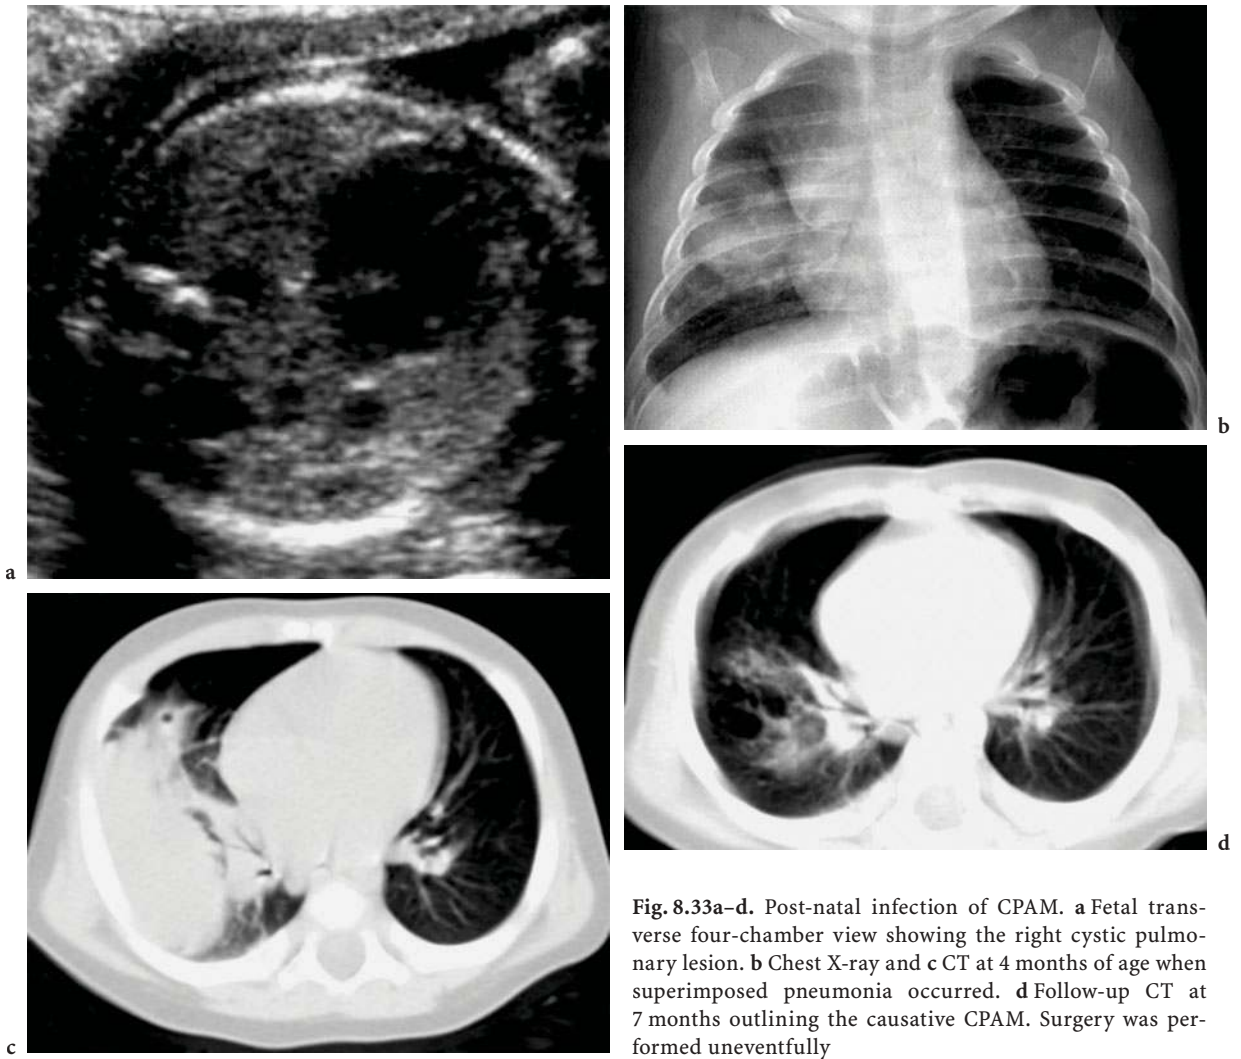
Post-natal infection of CPAM. a Fetal transverse four-chamber view showing the right cystic pulmonary lesion. b Chest X-ray and c CT at 4 months of age when superimposed pneumonia occurred. d Follow-up CT at 7 months outlining the causative CPAM. Surgery was performed uneventfully
